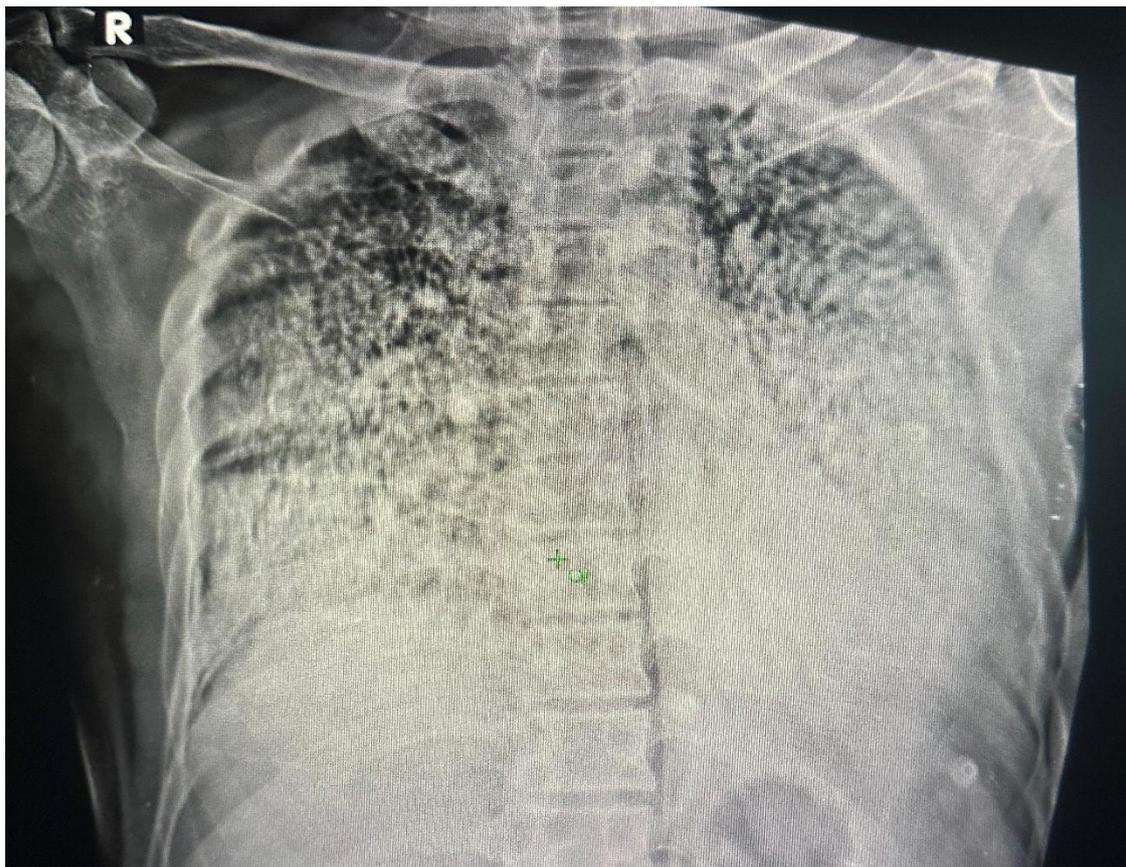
Frontal chest radiograph demonstrating the characteristic "sandstorm" appearance of pulmonary alveolar microlithiasis with diffuse bilateral micronodular opacities predominantly affecting the lower and middle lung zones, with preservation of cardiac and diaphragmatic contours.
